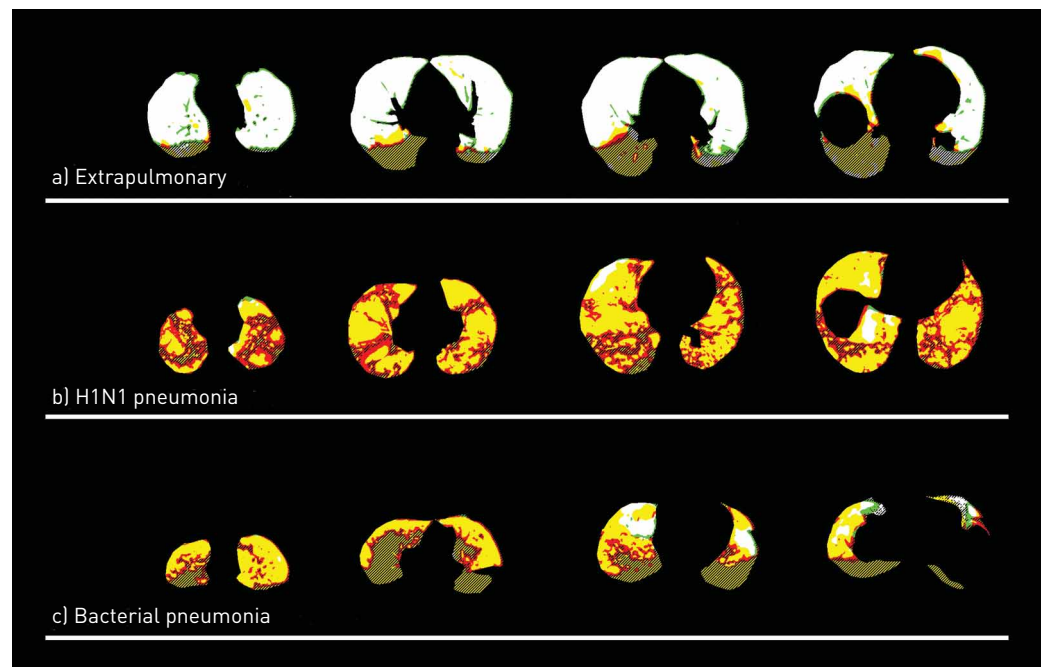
Interaction between [^{18}F]FDG uptake rate and lung inhomogeneity in pulmonary and extrapulmonary ARDS. Lung compartments at different lung levels from apex to base. Lung compartment colour code: white, homogeneous with normal [^{18}F]FDG uptake rate; green, inhomogeneous with normal [^{18}F]FDG uptake rate; yellow, homogeneous with high [^{18}F]FDG uptake rate; red, inhomogeneous with high [^{18}F]FDG uptake rate; shadowed areas represent not inflated tissue. Patient a) extrapulmonary ARDS (necrotising fasciitis with septic shock), $\text{PaO}_2/\text{FiO}_2$ 158, ICU outcome: alive. Patient b) pulmonary ARDS (H1N1-related pneumonia), $\text{PaO}_2/\text{FiO}_2$ 159, ICU outcome: alive. Patient c) pulmonary ARDS (bacterial pneumonia: methicillin-resistant *Staphylococcus aureus*) and septic shock, $\text{PaO}_2/\text{FiO}_2$ 183, ICU outcome: alive. See online supplementary material for images of all the patients. [^{18}F]FDG: [^{18}F]2-fluoro-2-deoxy-D-glucose; ARDS: acute respiratory distress syndrome; PaO_2 : arterial oxygen tension; FiO_2 : inspiratory oxygen fraction; ICU: intensive care unit.
